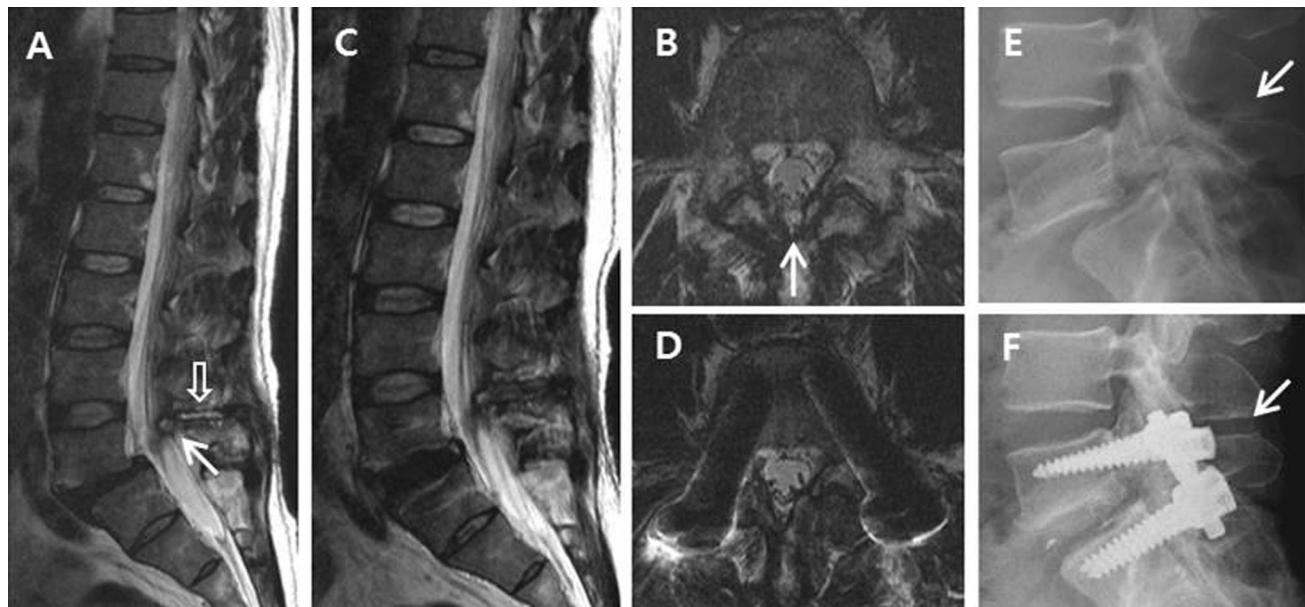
a, b T2-weighted magnetic resonance imaging (MRI) revealed an interspinous bursitis (*empty arrow*) and posterior epidural cyst (*white arrow*), with the resultant canal compromise. c, d Postoperative MRI showed a reduction in size of the cyst. e Preoperative lateral
